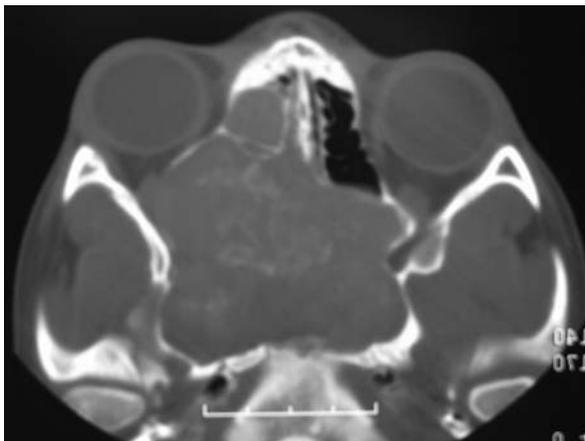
Axial computed tomography scan of the sinuses in a patient with allergic fungal sinusitis. There is dramatic expansion of the sphenoid sinus and hyperdensities within the sinus contents
